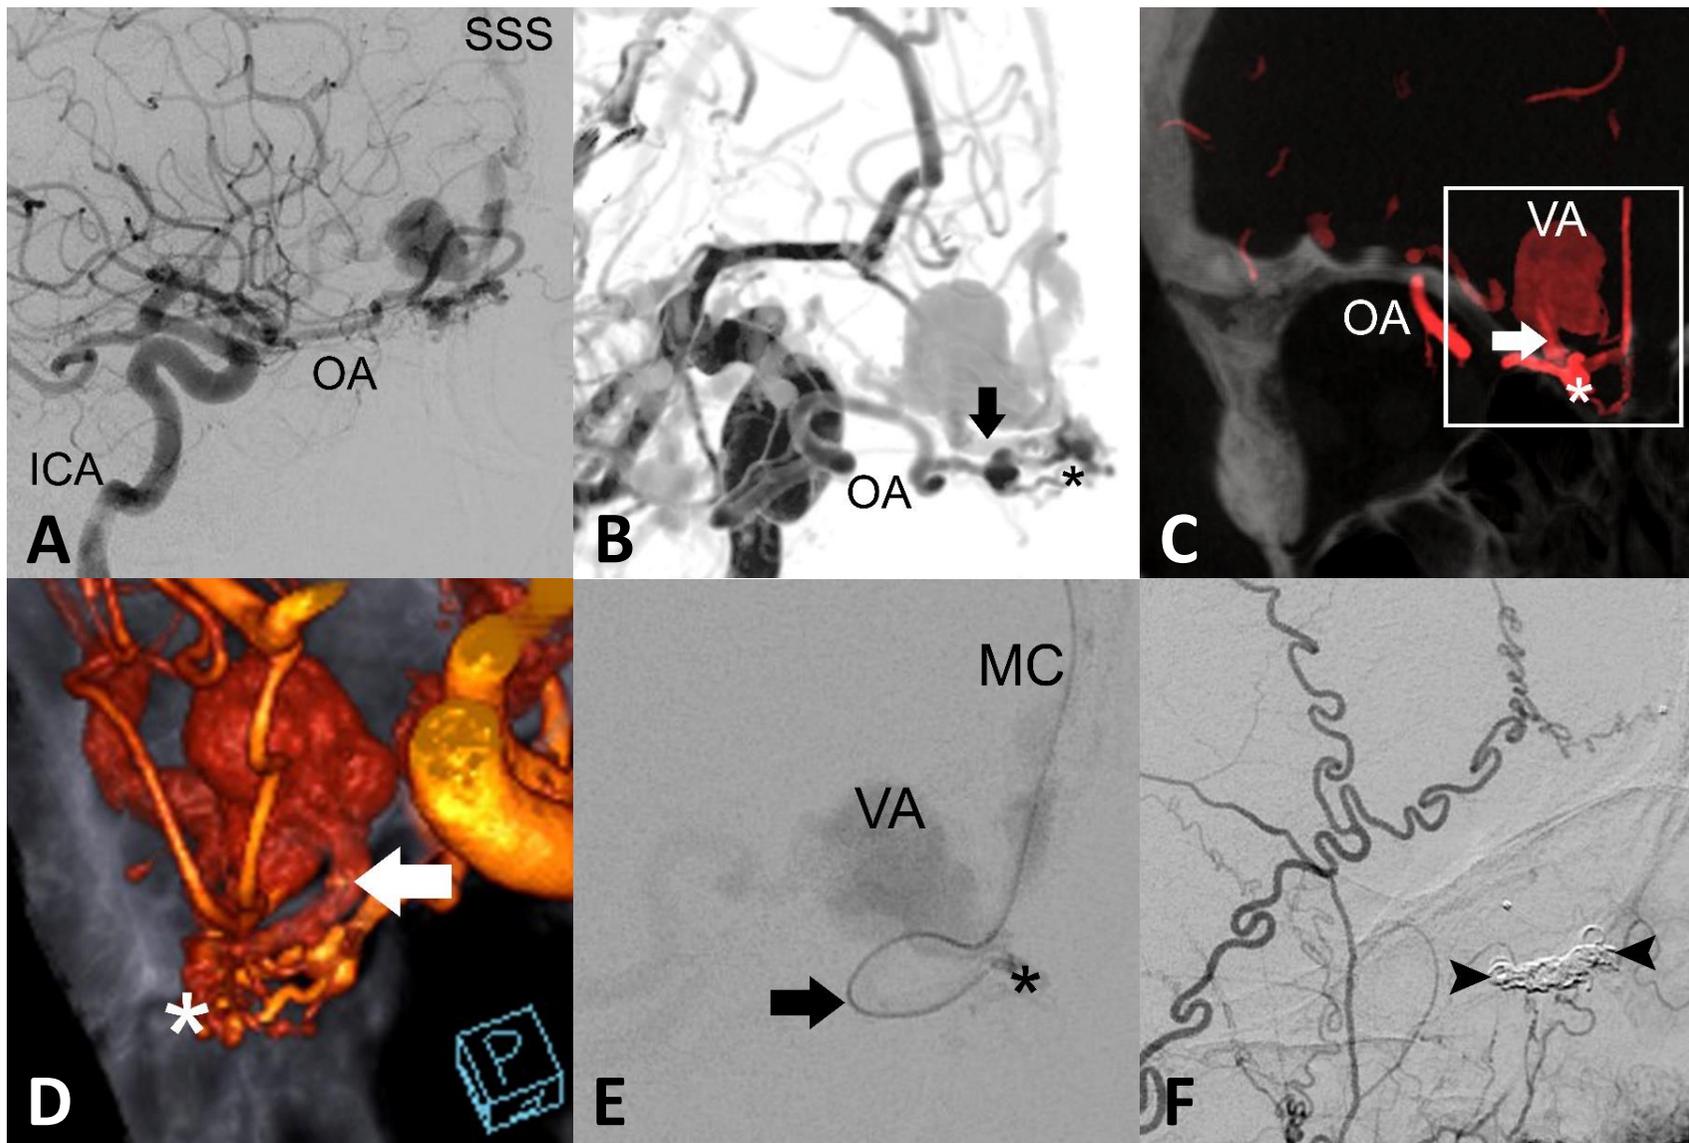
Comparison of a lateral standard projection in 2D-DSA (A) with an oblique projection in virtual DSA derived from 4D-DSA (B) and 4D-DSA coronal CT MIP (C) and volume rendering with an overlay of skull in an oblique zoomed-in projection (D). The 2D-DSA standard projection shows the frontoethmoidal DAVF supplied by the ophthalmic artery (OA) with drainage into the cortical veins and then the superior sagittal sinus (SSS). 4D-DSA images offer better visualization of the frontoethmoidal fistulous point (asterisk) and its anatomic relation to the draining vein (arrow), which is obscured in the standard projection of 2D-DSA, and the following venous aneurysm (VA). Note that the fistulous point is located within the olfactory groove. For the endovascular therapy, a transvenous approach is selected with superselective positioning of the microcatheter (MC) in the draining vein past the venous aneurysm (E), close to the fistulous point. After coiling (arrowheads) of the draining vein (F) we achieved complete embolization of the DAVF, as seen in the control angiogram of the external carotid artery.
